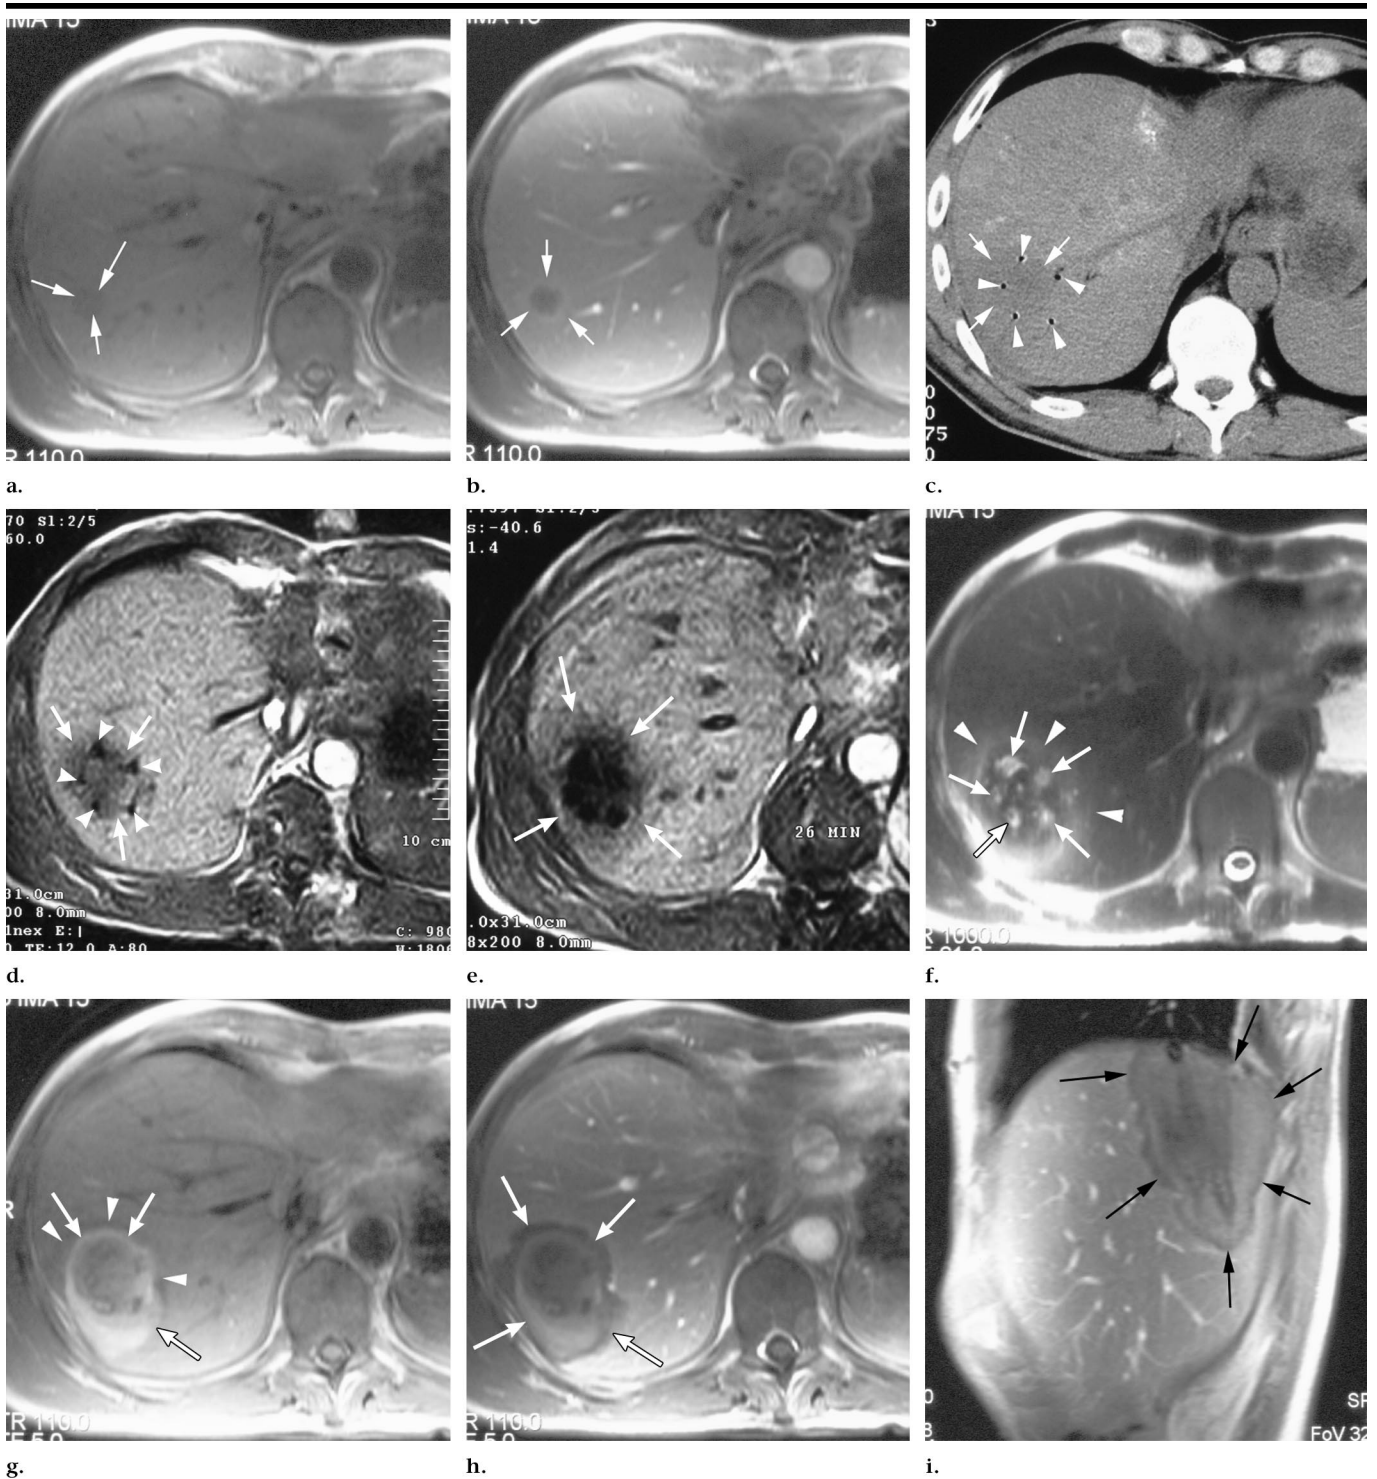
Transverse Images of liver metastasis of colorectal cancer in 40-year-old man. (a) Unenhanced T1-weighted gradient-echo MR image (110/5) obtained 3 weeks before LITT shows liver metastasis (arrows) in segments VII and VIII with maximum diameter of 2.5 cm. (b) Contrast-enhanced T1-weighted gradient-echo MR image (110/5) obtained 3 weeks before LITT shows enhancement in periphery of metastasis (arrows). (c) CT image obtained on day of treatment shows obvious progression of lesion (arrows) in segments VII and VIII with maximum diameter of 4.5 cm (compare with a and b). Note placement of five laser fibers (arrowheads) in periphery of metastasis. (d) Unenhanced MR image (140/12) obtained immediately before LITT shows metastasis (arrows) and laser fibers (arrowheads). (e) Unenhanced T1-weighted MR image (140/12) obtained 26 minutes into LITT demonstrates signal intensity decrease in lesion (arrows) and surrounding tissue as result of increase in tissue temperature (compare with d). Lesion temperature is approximately 110°C in the center and 60°–70°C in the peripheral zone. (f) Unenhanced T2-weighted MR image (3,000/92) obtained 24 hours after LITT shows coagulation area (arrows) with surrounding reactive changes and edema (arrowheads). (g) Unenhanced T1-weighted gradient-echo MR image (110/5) obtained 24 hours after LITT demonstrates typical pattern of coagulation area after LITT with hyperintense pattern (arrows) in periphery, probably a result of slight hemorrhage into the lesion. Corresponding to the hyperintense area in f, lesion is surrounded by a hypointense rim (arrowheads) as a result of edema and reactive changes. (h) Contrast-enhanced T1-weighted MR image obtained 24 hours after LITT shows induced coagulation area (arrows). (i) Sagittal contrast-enhanced T1-weighted gradient-echo MR image obtained 24 hours after LITT demonstrates volume of necrosis (arrows), which exceeds initial tumor size by a factor of 4.
